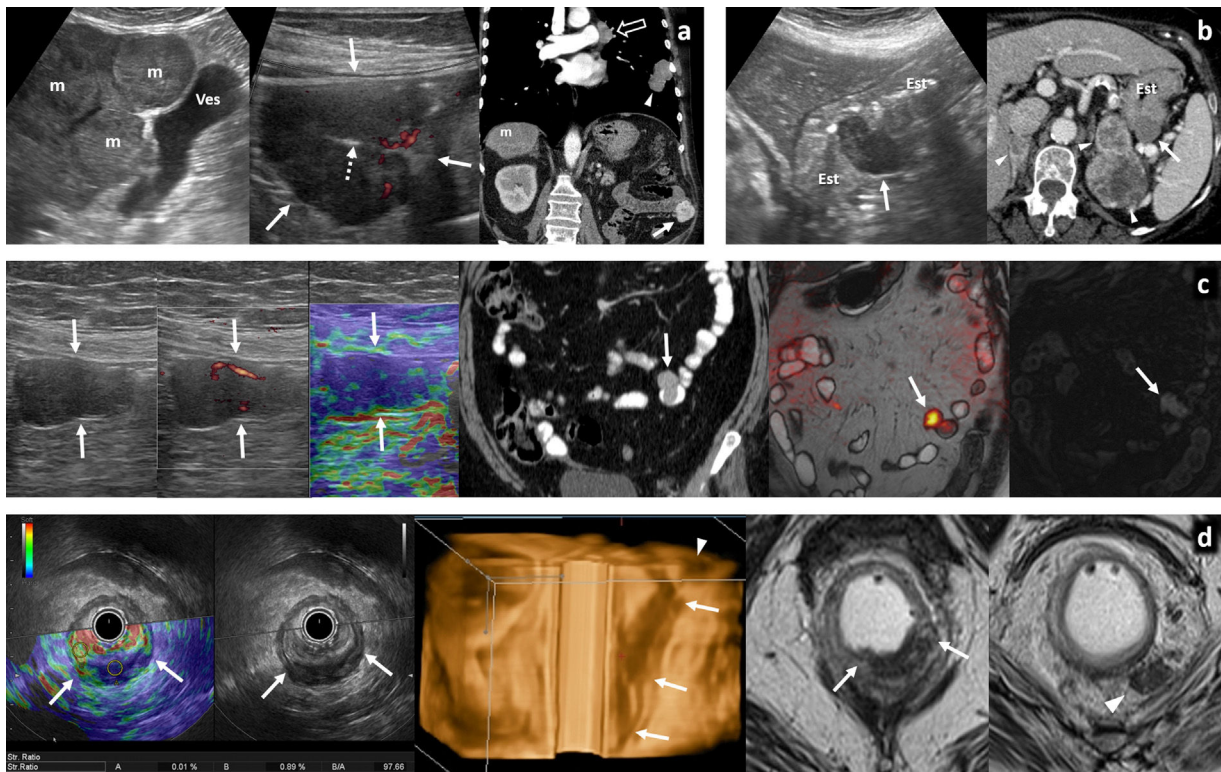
Bowel metastasis. A) Ulcerated jejunal metastasis of a pulmonary neuroendocrine tumour. 65-year-old male. Constitutional syndrome. From left to right: liver ultrasound, left flank ultrasound, and coronal contrast-enhanced computed tomography (CT). Primary lung tumour (arrowhead), mediastinal lymphadenopathy (empty arrow), liver metastases (m), and hypoechoic and hypervascular jejunal metastases (arrows), with ulceration (broken arrow). B) Gastric metastasis of clear-cell renal cell carcinoma. 72-year-old female. Left image: longitudinal ultrasound in epigastrium. Right image: axial CT with contrast. Hypoechoic lobulated metastasis (arrows) in the posterior wall of the body of the stomach (St). There are also adrenal (arrowheads), cardiac, peritoneal, bone and soft tissue metastases (not shown). C) Endo- and exophytic jejunal metastasis of acral lentiginous melanoma. 56-year-old female. From left to right: left flank ultrasound, Doppler ultrasound, strain elastography, coronal CT with oral and intravenous contrast, coronal fusion/diffusion T2-weighted magnetic resonance (MR) enterography, coronal T1-weighted image without contrast. Lobulated metastasis, with an endophytic and an exophytic component in a stretch of jejunum (arrows). It is hypoechoic, moderately vascularised, stiff on elastography, homogeneous on CT, with diffusion restriction and moderately hyperintense on T1-weighted images due to melanin content. D) Anorectal melanoma. 64-year-old female. From left to right: strain elastography and transrectal ultrasound in lower rectum, 3 D reconstruction of endorectal ultrasound, axial T2-weighted magnetic resonance imaging (MRI) in a lower and upper plane. Infiltrating lesion in the posterior wall of the lower rectum and anus with great tissue stiffness (strain ratio of 97.66), embedded in the submucosa with mucosal and transmural infiltration (arrows), as well as peri-rectal lymphadenopathy (arrowheads). There was also invasion of extramural veins and liver metastases (not shown). No cutaneous melanoma was found.
